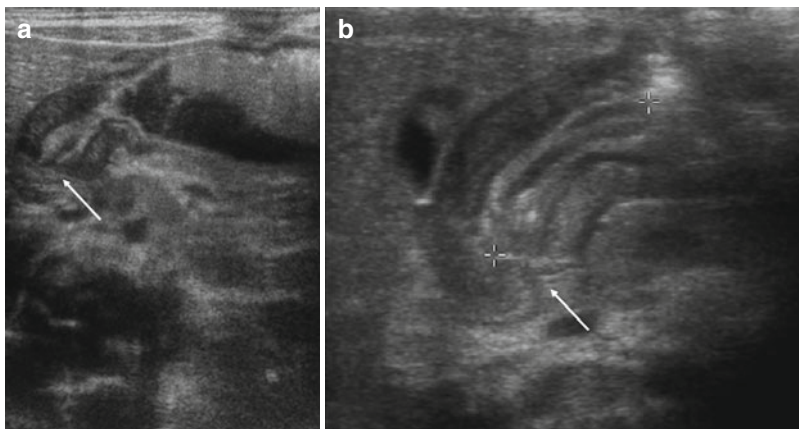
(a, b) Ultrasound longitudinal scan shows “portio sign” due to the protrusion of the pylorus (*white arrow*) in the duodenal bulb
